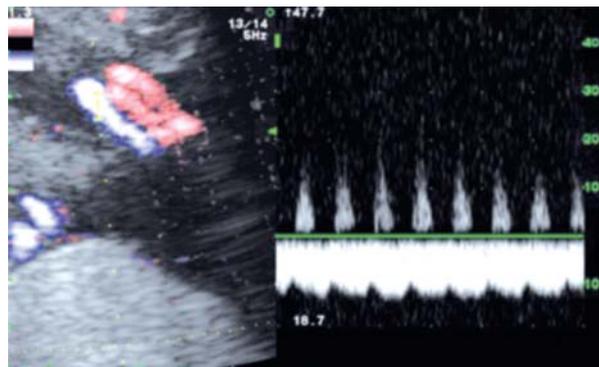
Doppler waveforms in the donor fetus complicated with twin-twin transfusion syndrome stage 3. Absent end-diastolic flow in the umbilical artery and pulsatile waveform in the umbilical vein
